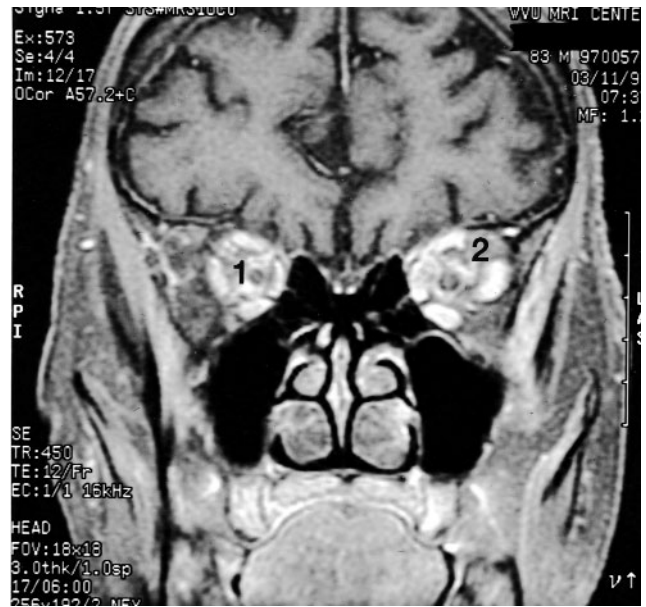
MRI of the brain and orbits was performed with gadolinium and fat saturation. T1 weighted coronal image shows bilateral enhancement of the optic nerve sheaths (1) and adjacent orbital fat (2).
